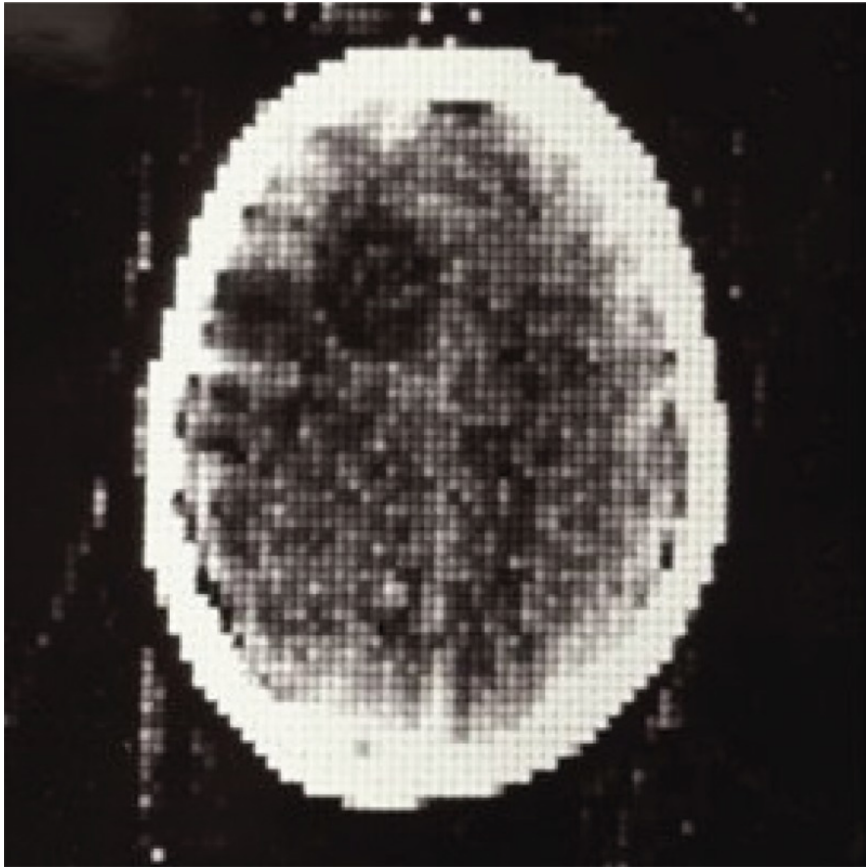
Early clinical CT scan of a brain with a lesion
